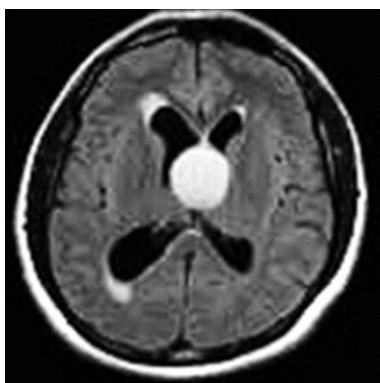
CT image of colloid cyst
